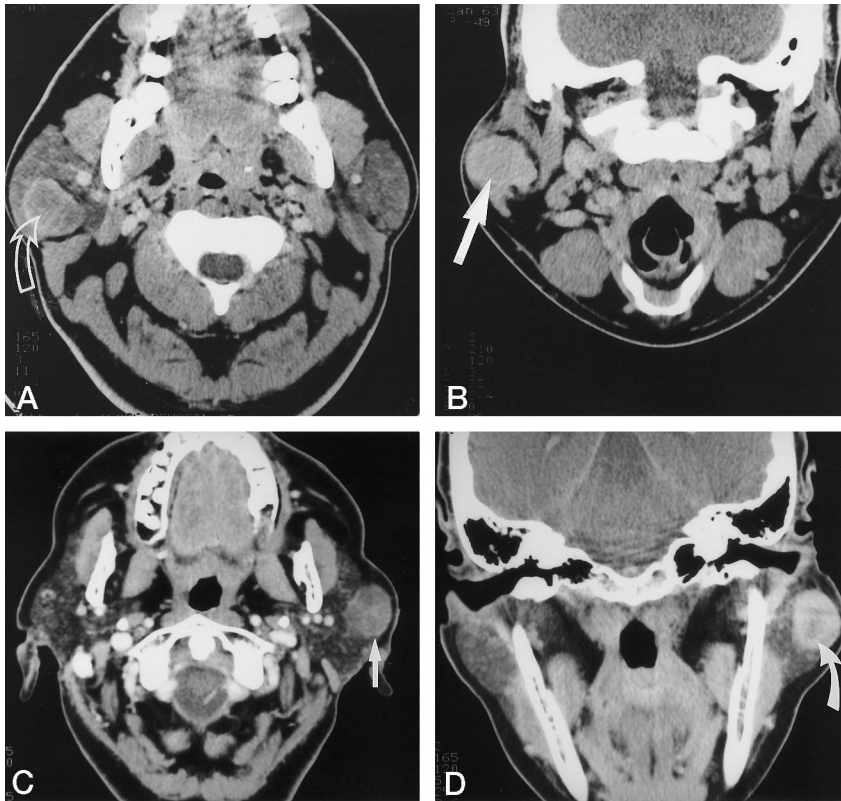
A, Axial CT scan of a typical parotid pleomorphic adenoma, obtained 7 minutes after IV administration of contrast material (arrow). The lesion has distinct margins. Note the thin peripheral rim of enhancement, the slightly reticular pattern of enhancement just deep to this, and the relative lack of central enhancement.
